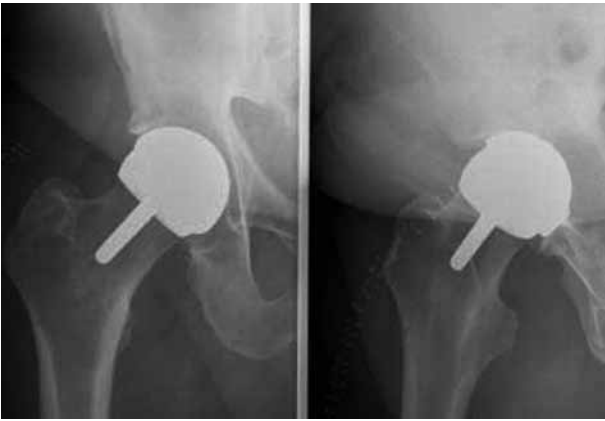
Postoperative radiograph of the Birmingham hip resurfacing.
